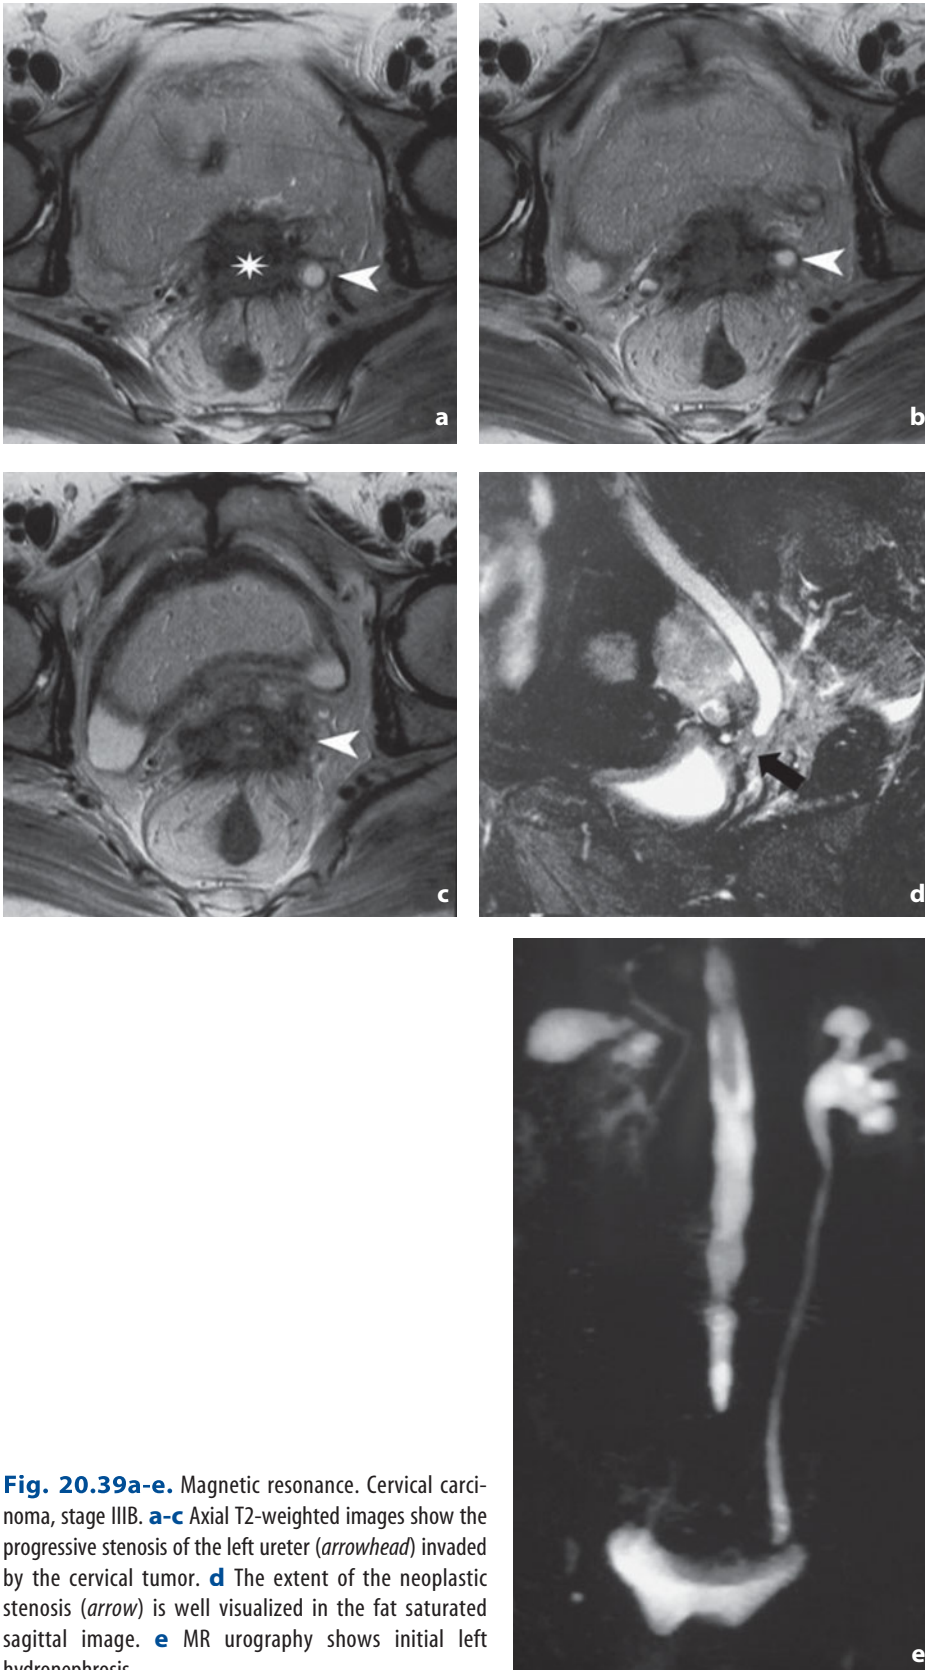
Magnetic resonance. Cervical carcinoma, stage IIIB. a-c Axial T2-weighted images show the progressive stenosis of the left ureter (*arrowhead*) invaded by the cervical tumor (*star*). d The extent of the neoplastic stenosis (*arrow*) is well visualized in the fat saturated sagittal image. e MR urography shows initial left hydronephrosis
